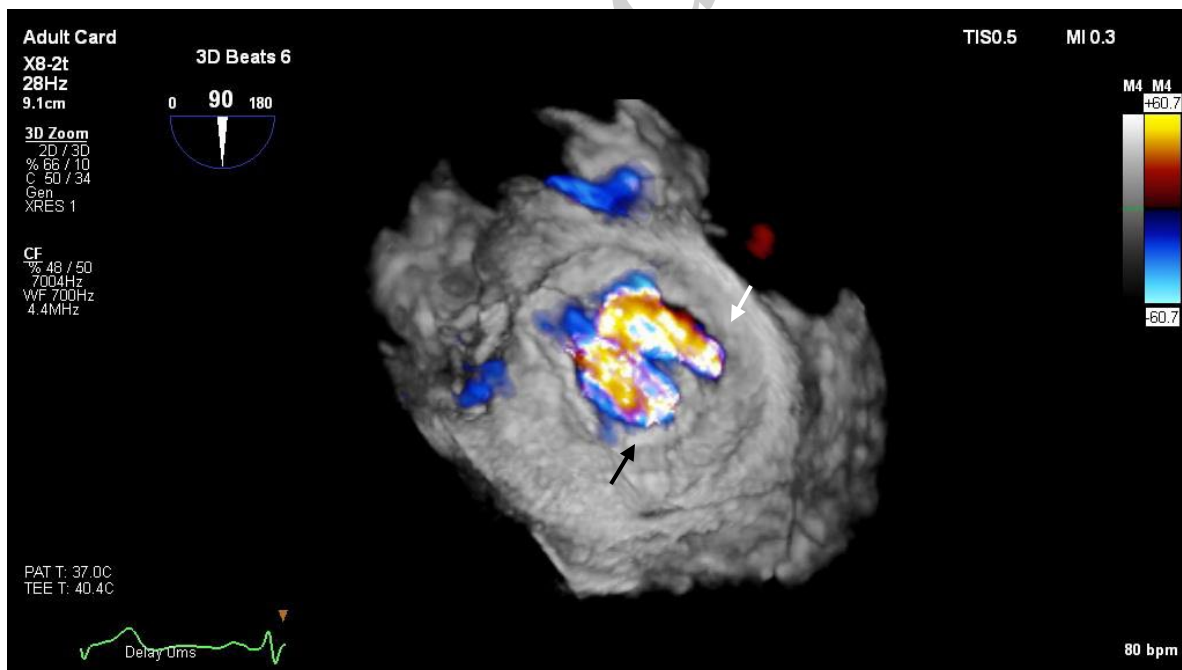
Three-dimensional echocardiogram displaying two distinct MR jets: one emanating through the prosthetic valve itself (black arrow) and another through the area of dehiscence (white arrow).
